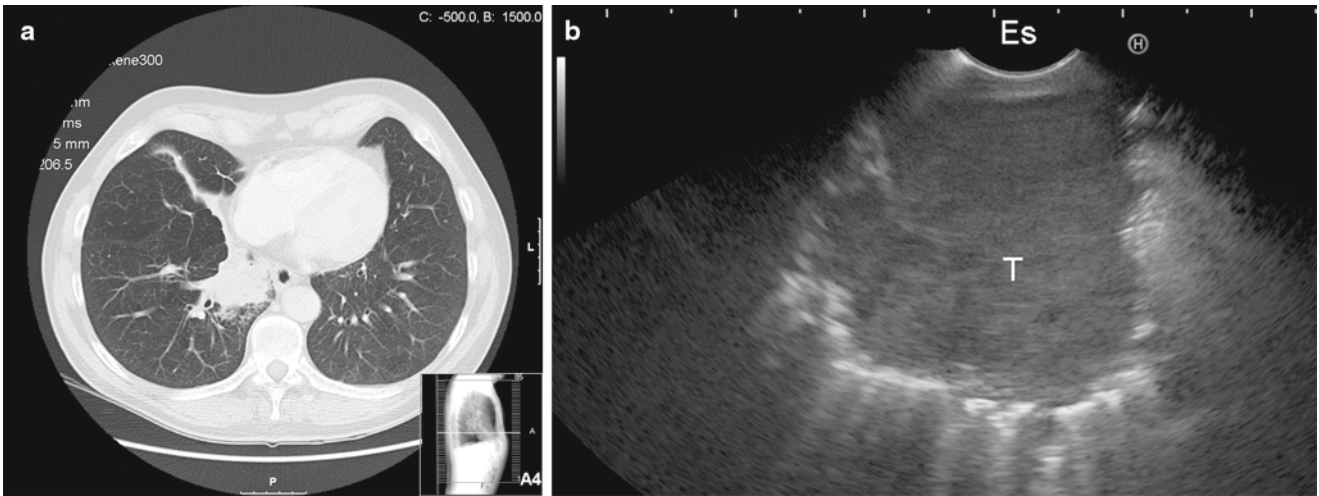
(a) CT scan of the chest showing a centrally located right lower lobe tumor. No diagnosis was obtained with bronchoscopy. (b) Corresponding EUS image showing the right lower lobe tumor (*T*) from the esophagus (*ES*). The diagnosis squamous cell carcinoma was made by EUS-FNA
